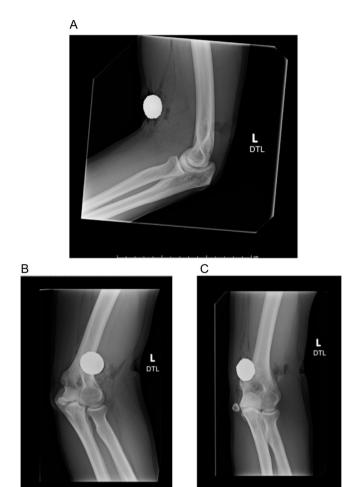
A (lateral), 2B (oblique), and 2C (AP) show the complete left elbow x-ray of a 27-year-old male presenting after an altercation with law enforcement. A 3.0 \times 2.3 cm lobular well circumscribed metallic density is visualized. Additionally, a 2.1 cm skin laceration with soft tissue swelling and subcutaneous emphysema in the lateral soft tissues at the level of the distal humerus reveals the entry wound.
